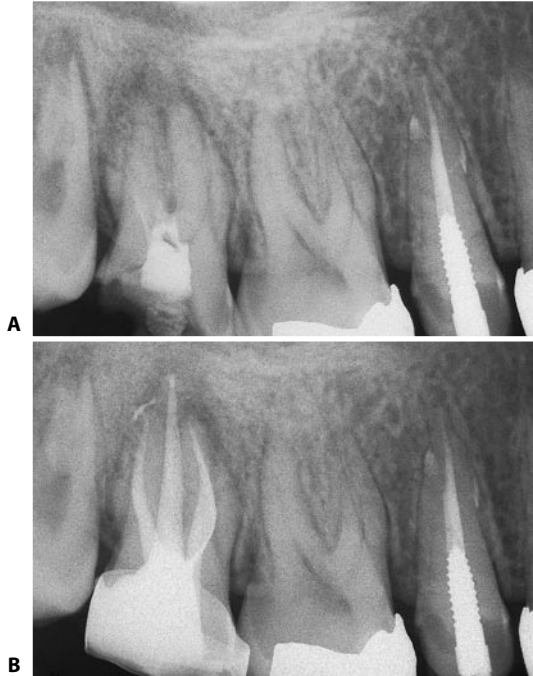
A. Preoperative radiograph of an upper right second molar. B. Postoperative radiograph. The mesiopalatal canal has the appearance of a radiopaque loop superimposed on the image of the mesiobuccal canal into which it merged.
